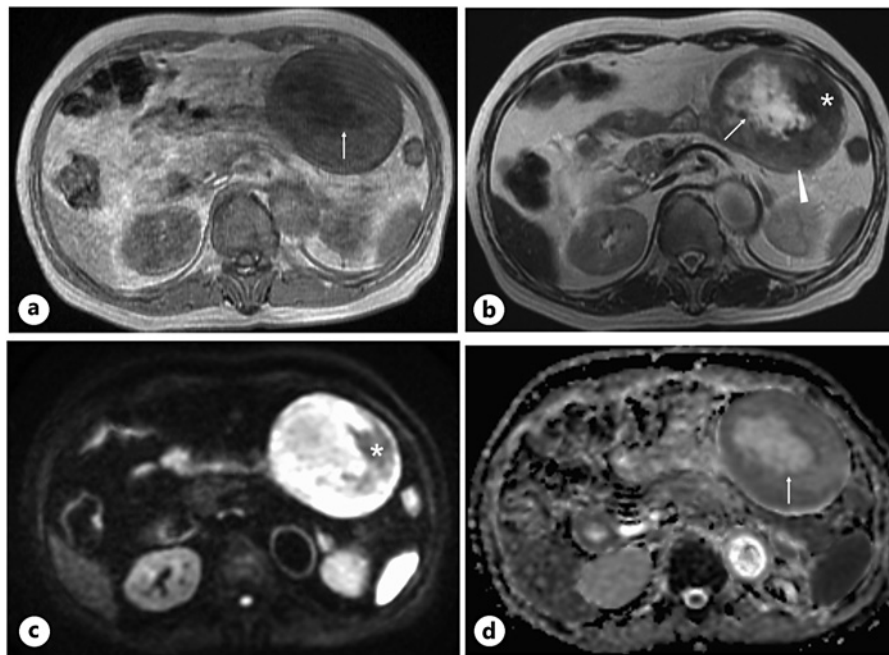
Magnetic resonance image (MRI) findings. a T1-weighted images showed a hypo-intense oval mass with more hypo-intense areas (arrow) in the center of the tumor. b T2-weighted images showed hyper-intense areas (arrow), hypo-intense areas (arrowhead), and more hypo-intense areas (asterisk) in the tumor. c DWIs showed a hyper-intense pattern except for some areas of the tumor borders (asterisk). d ADC images showed the center of the tumor to be somewhat hyper-intense (arrow).
